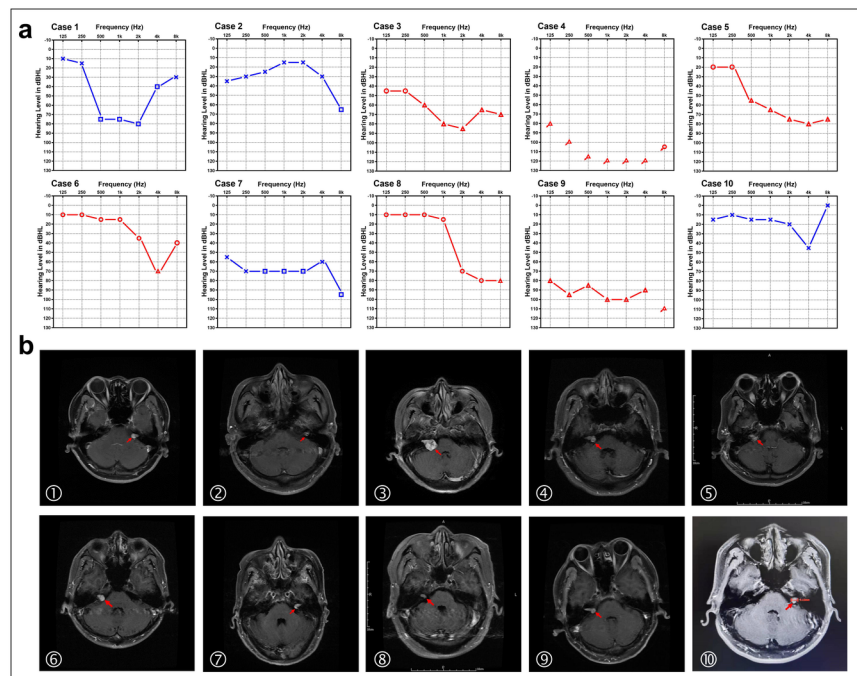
Figure 1: (a) Pure-tone audiograms of the affected ear of the 10 acoustic neuroma patients at diagnosis of sudden sensorineural hearing loss (air conduction). The red line represents the right ear and the blue line represents the left ear. (b) The axial cranial MRI of the 10 patients diagnosed with acoustic neuroma in our study. Red arrows indicate the tumor location.
